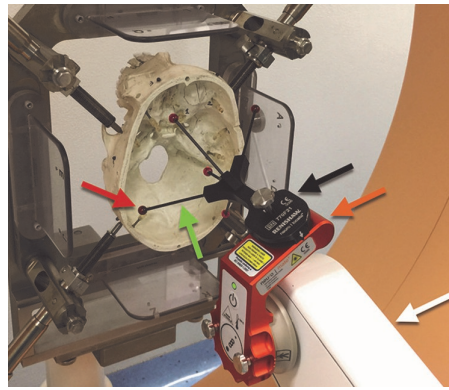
An overview of the Neurolocate registration device as described by Cardinale et al. (2017). This device has five ruby balls (red arrows) which are referred to as the Neurolocate FMs, and are attached to an FM frame (black arrow) with carbon-fibre rods (green arrow). This frame is attached to a laser tool holder (white arrow), which is mounted to the arm of a 5DOF passive robot. Then the Neurolocate is moved very close to the patient's head; an intraoperative CT scan provides 3D data, and registration is performed with a specific software module that selects the centre of the FMs. The five positions are sent to the robot, and the transformation matrix is calculated (2017).
